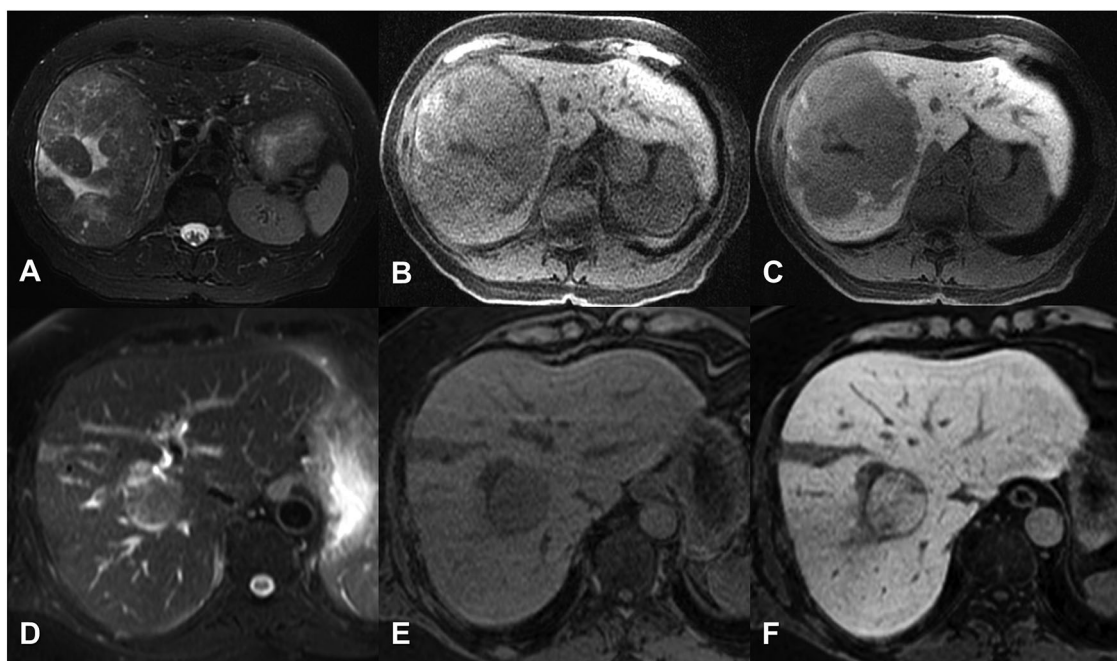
Axial magnetic resonance imaging on a separate patient performed with hepatobiliary contrast agent (gadoxetate) in two separate patients. Axial T2-weighted (A) and pre-contrast T1-weighted (B) demonstrates a large hepatocellular carcinoma in the right liver with minimal uptake on hepatobiliary phase imaging (C). This contrasts to the second patient with HCC that also shows mild hyperintensity on T2-weighted (D) and hypointensity on T1-weighted (E) but demonstrates uptake of contrast in the hepatobiliary phase (arrow, F).
